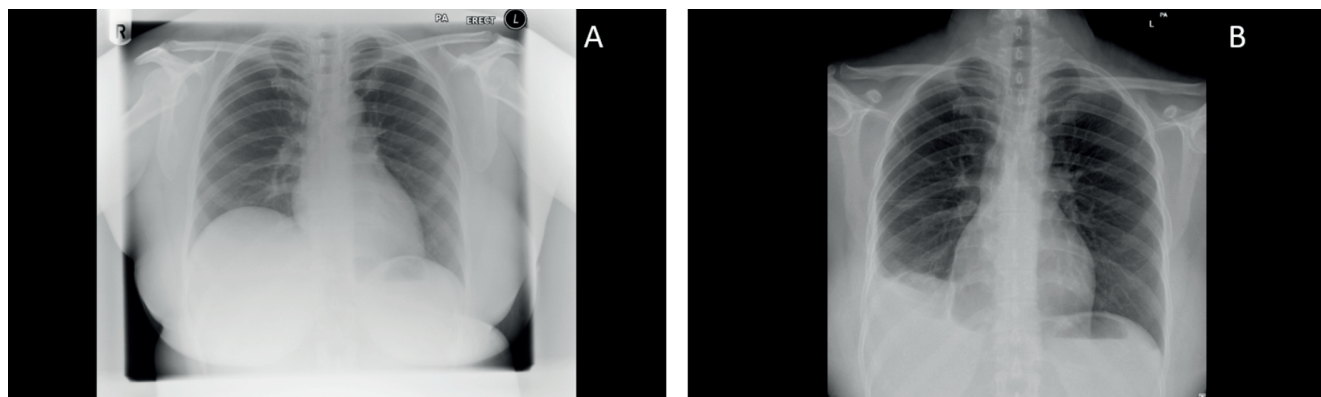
A) Chest radiograph of a 39-year-old woman showing elevation of the right hemidiaphragm post COVID-19. B) Chest radiograph of the same patient following robotic-assisted surgical plication showing improved position of the right hemidiaphragm.
